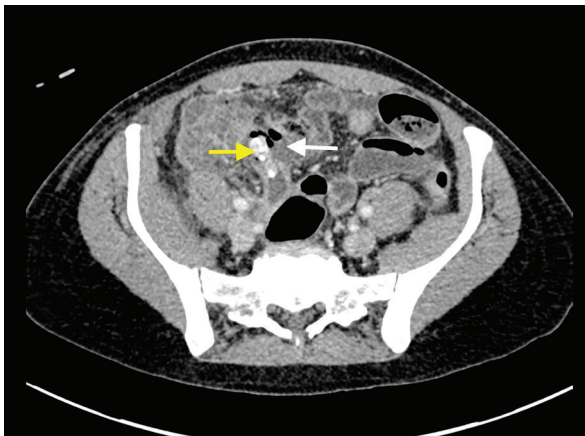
Computed tomography demonstrating acute appendicitis secondary to a high density appendicolith (yellow arrow) associated with perforation of the appendix and adjacent peritoneal free fluid and free gas (white arrow).
